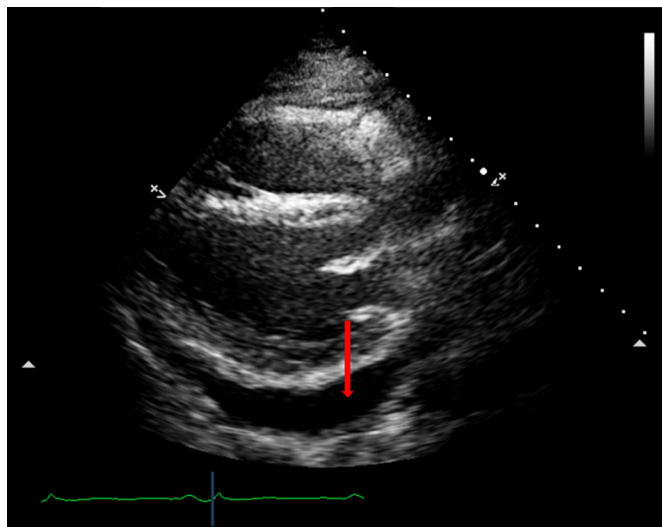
Echocardiographic image of the heart in the longitudinal plane showing pericarditis (red arrow) in a patient with myositis. Adapted from the personal collection of Mikkel Hougaard, MD, PhD, Odense University Hospital, Denmark.
